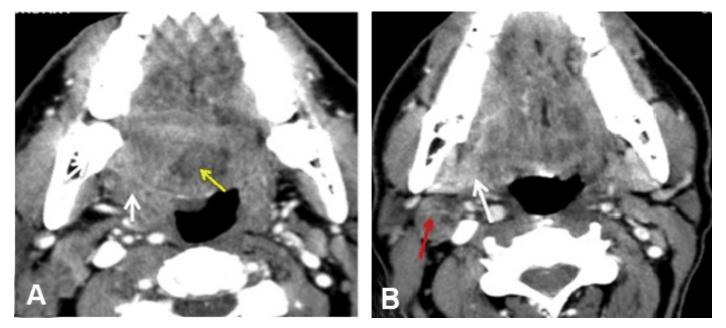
(A) Comparative axial post contrast CT images showing a mass (white arrow) infiltrating the right base of the tongue, with a hypo-dense central component (yellow arrow) causing distortion of the oropharynx and crossing the midline. The margins of the entire lesion are difficult to determine, (B) Right cervical lymphadenopathy is evident (red arrow) (Case 1).
